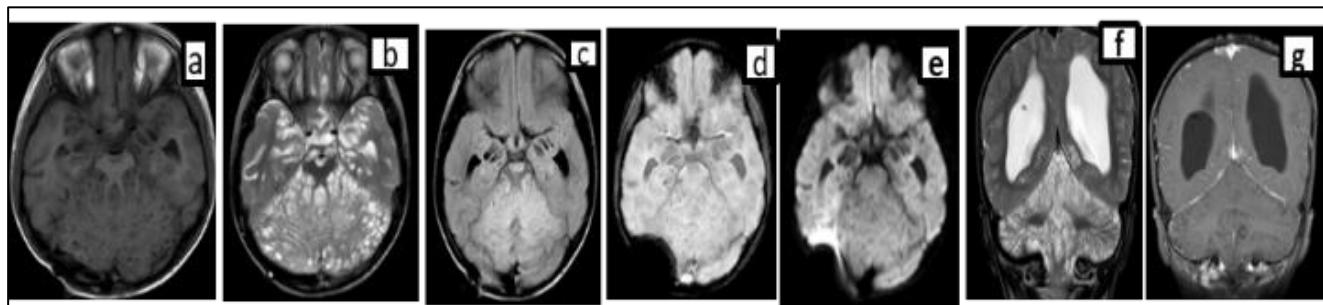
(a-g): MRI findings of DL-GNT.
